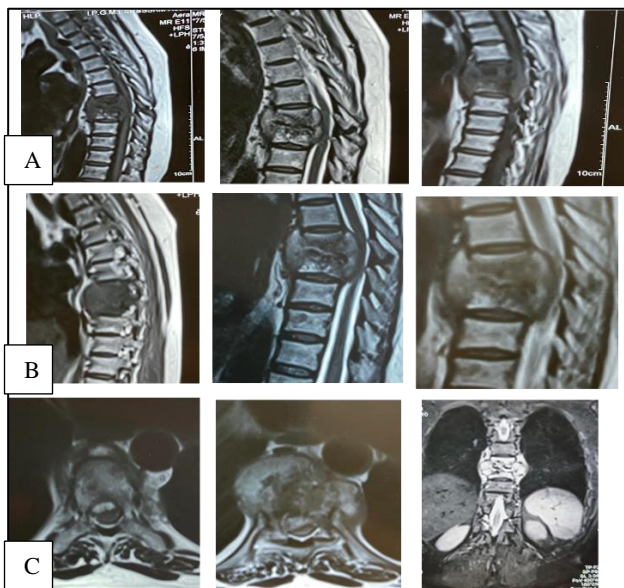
(A-C): Pre-op MRI of compression of cord by liquid pus from anterior into extradural space with alteration of cord signal.
